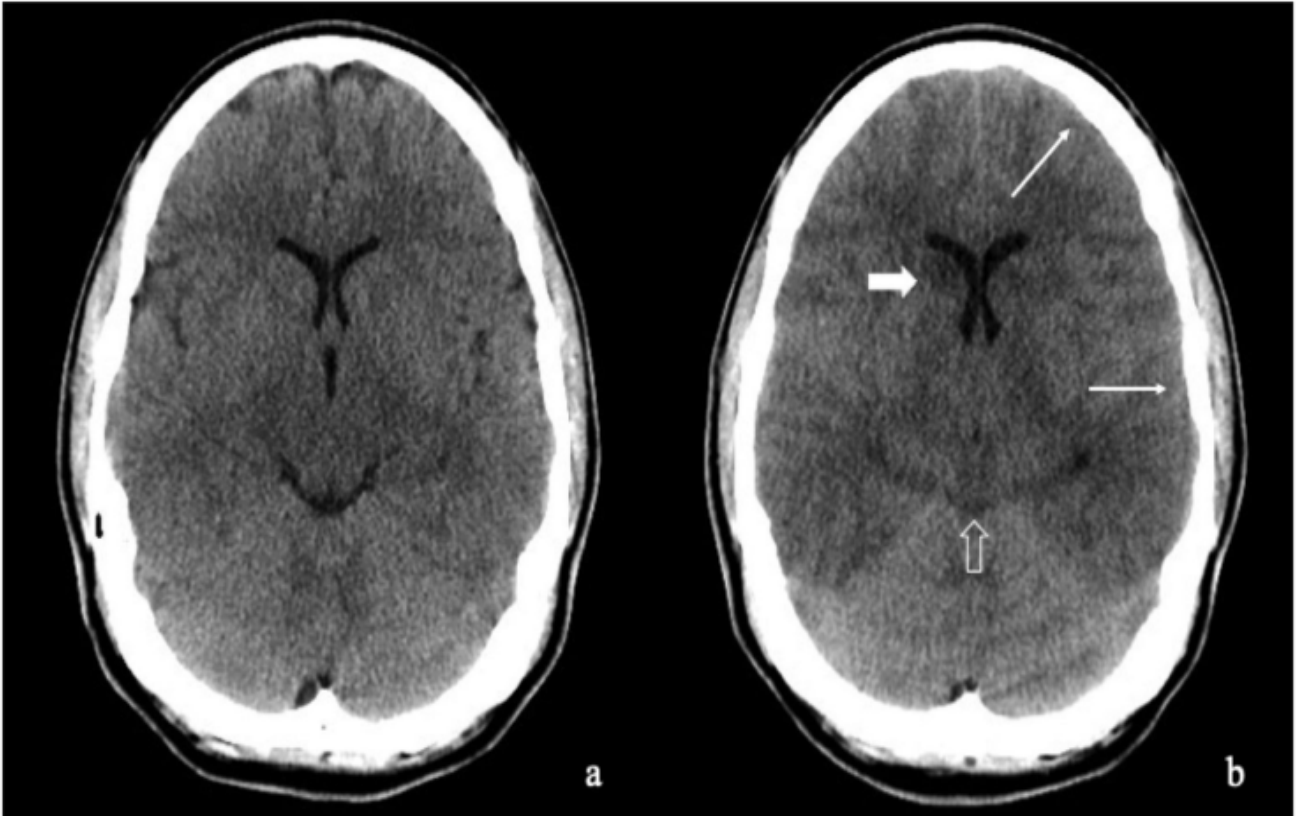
Brain CT of patient with CFE, a) at the time of trauma, b) after 24 hrs.
